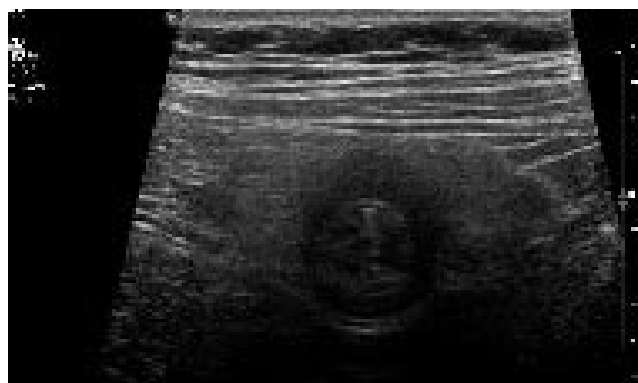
Ultrasonography of the mass shows a multilocular cystic lesion with septa.
